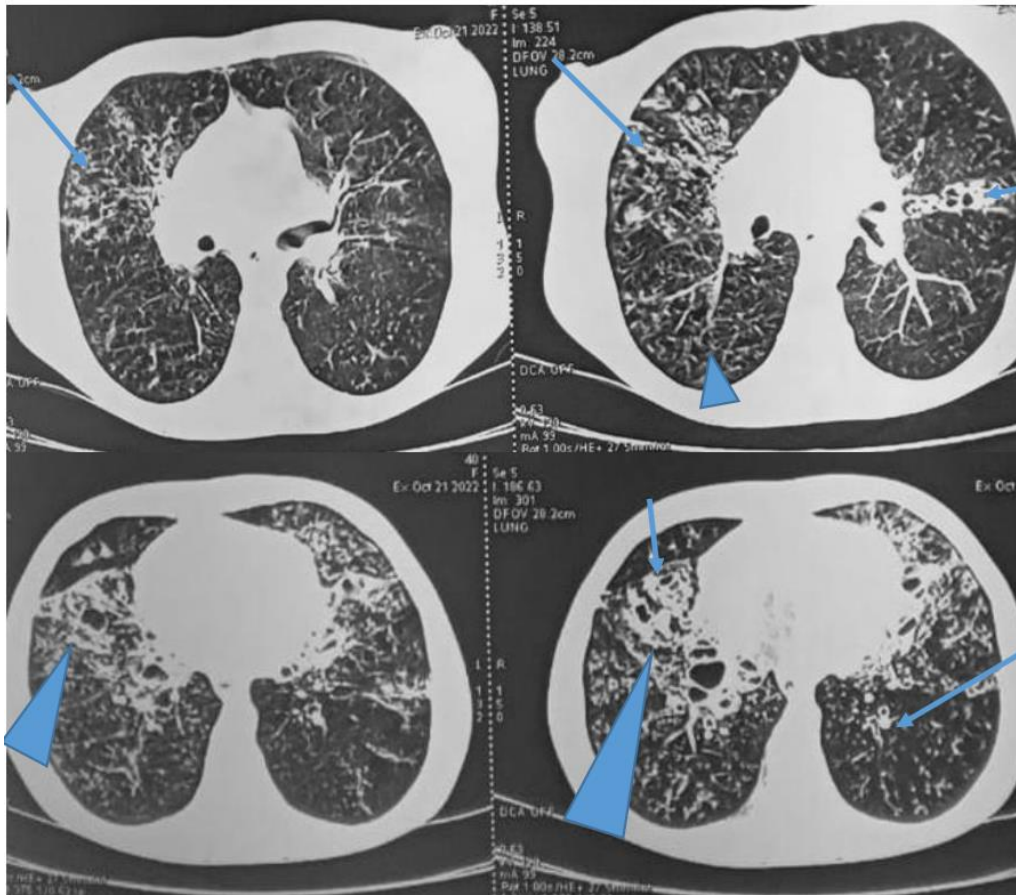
Chest CT scan, cross section (parenchymal window); Image A: shows alveolar-interstitial damage (); Image B: shows the dilations of the bronchi ()
